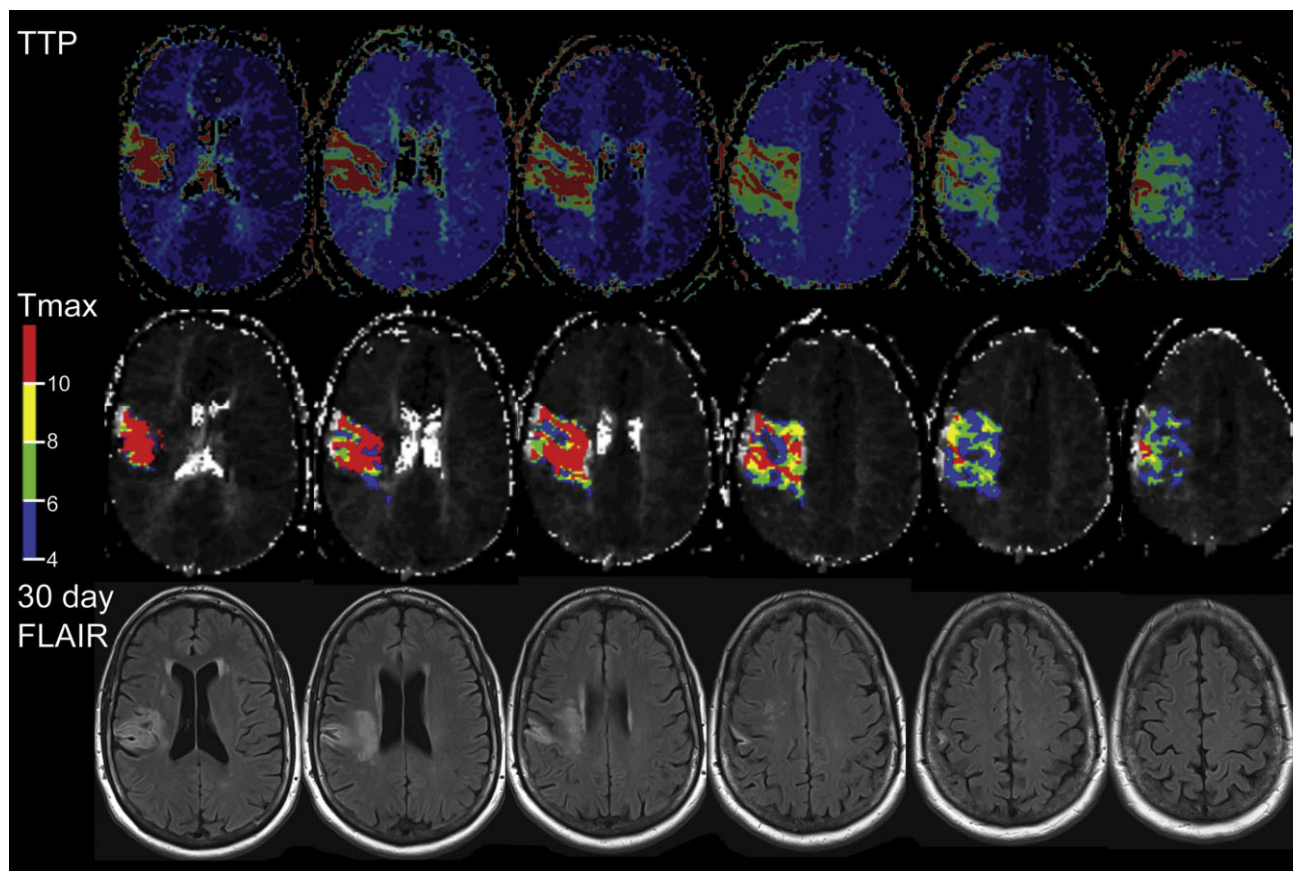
Example of perfusion MRI in an acute ischemic stroke patient. Time to Peak (TTP) map generated by manufacturer's software demonstrates a clear abnormality in the right middle cerebral artery territory. However, without thresholding it is difficult to distinguish 'benign oligemia' from tissue at risk of infarction. The Tmax map (RAPID, Stanford University) quantifies the perfusion delay. Use of a Tmax >6 s threshold reduces the overestimation of tissue at risk, as seen when compared to the day 30 FLAIR in this patient who did not receive reperfusion therapy. MRI: Magnetic resonance imaging.
